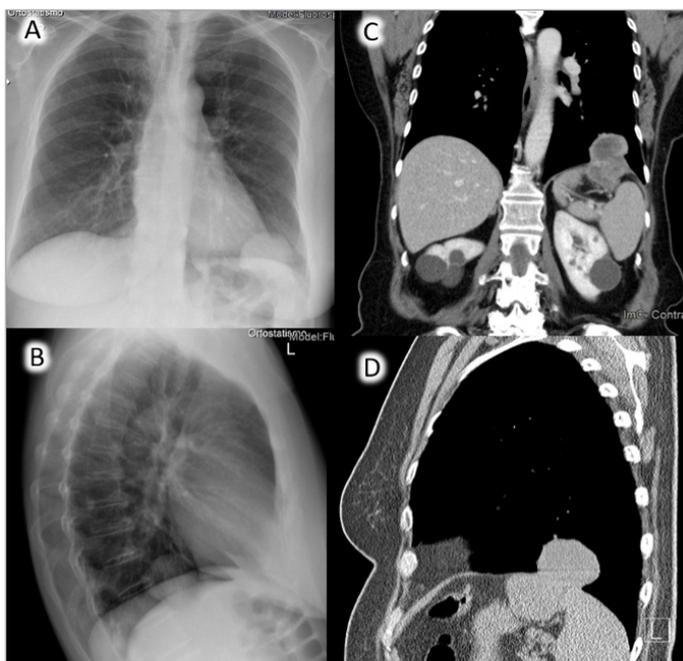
Figure #969: Figure A and B - Antero-posterior and lateral incidences of plain radiography. Figure C and D - coronal and sagittal plane of CT.
